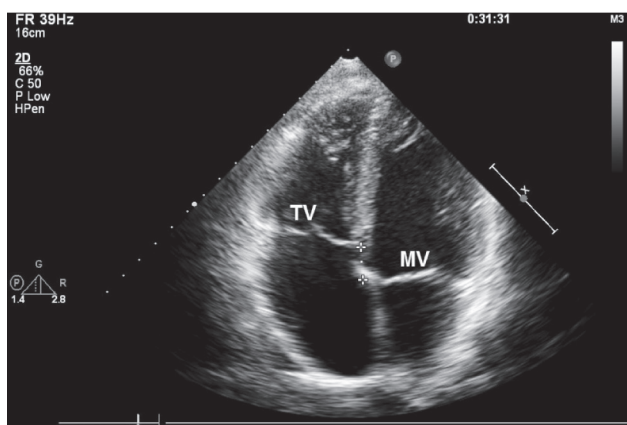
Two-dimensional echocardiography (four-chamber view) depicts the attachment of the septal and posterior leaflets of the tricuspid valve (TV) displaced apically (by 15 mm) in comparison with the attachment of the anterior (septal) leaflet of the mitral valve (MV), all consistent with mild-to-moderate Ebstein's anomaly. While the septal and posterior tricuspid leaflets are mildly hypoplastic, the anterior tricuspid leaflet (not shown) was big, sail-like, and its attachment to the right ventricular free wall almost normal.
